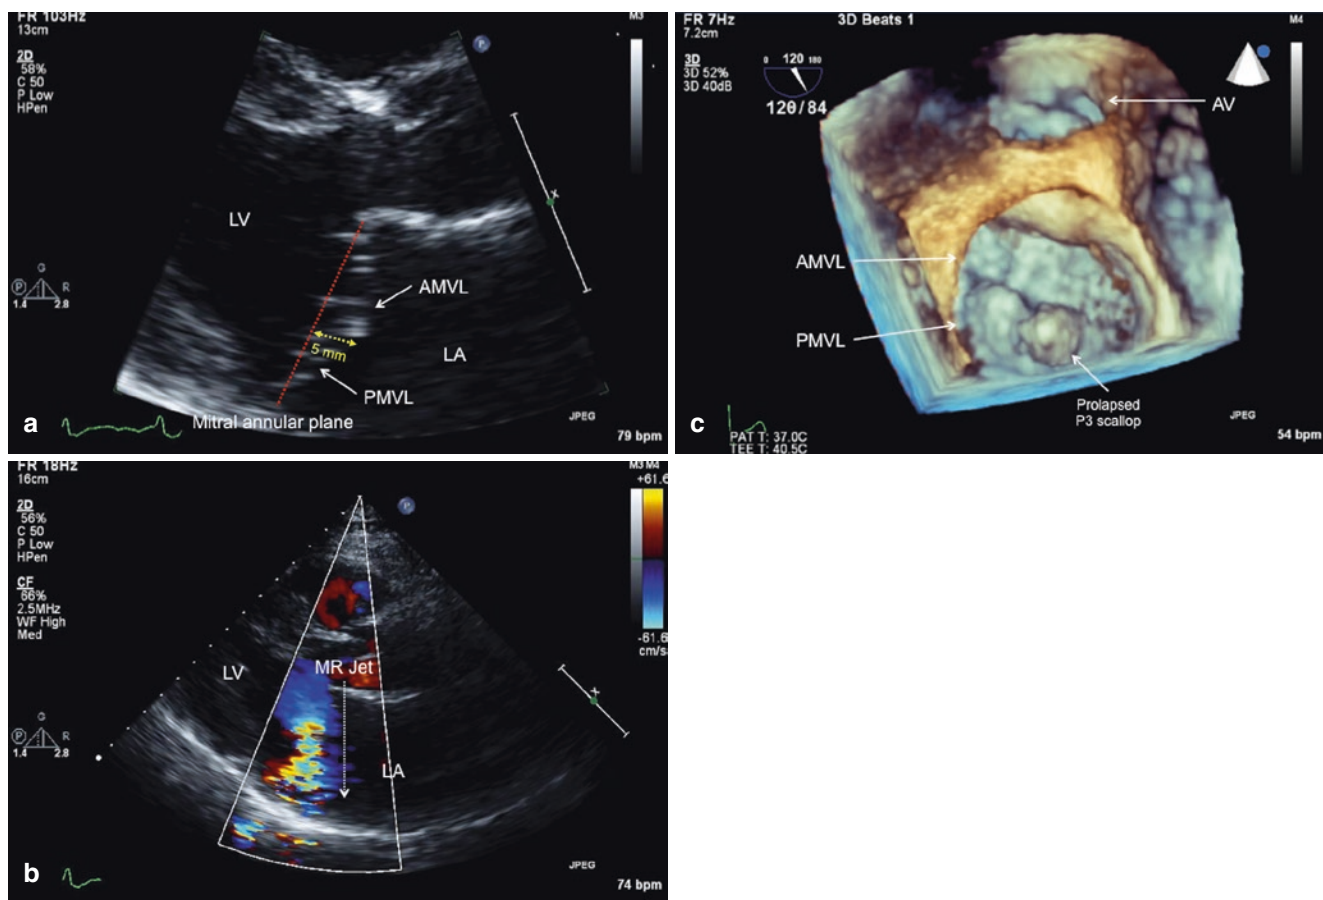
Echocardiographic appearance of mitral valve prolapse. In a normal functioning mitral valve, the leaflets meet in the left ventricle during systolic to prevent significant regurgitation. In mitral valve prolapse, there is redundant leaflet tissue. As a result of this redundant leaflet tissue, during systole, one or both mitral leaflets billow back into the left atrium with the anterior leaflet prolapsing more than the posterior leaflet, ~5 mm (shown in yellow) beyond the mitral annular plane. Because of the redundant tissue, the leaflets coapt poorly, and significant regurgitation can occur. Panel B is a color Doppler assessment of this same patient demonstrating significant eccentric posteriorly directed mitral regurgitation (represented by the dotted white line). There exist multiple qualitative, semiquantitative, and quantitative
